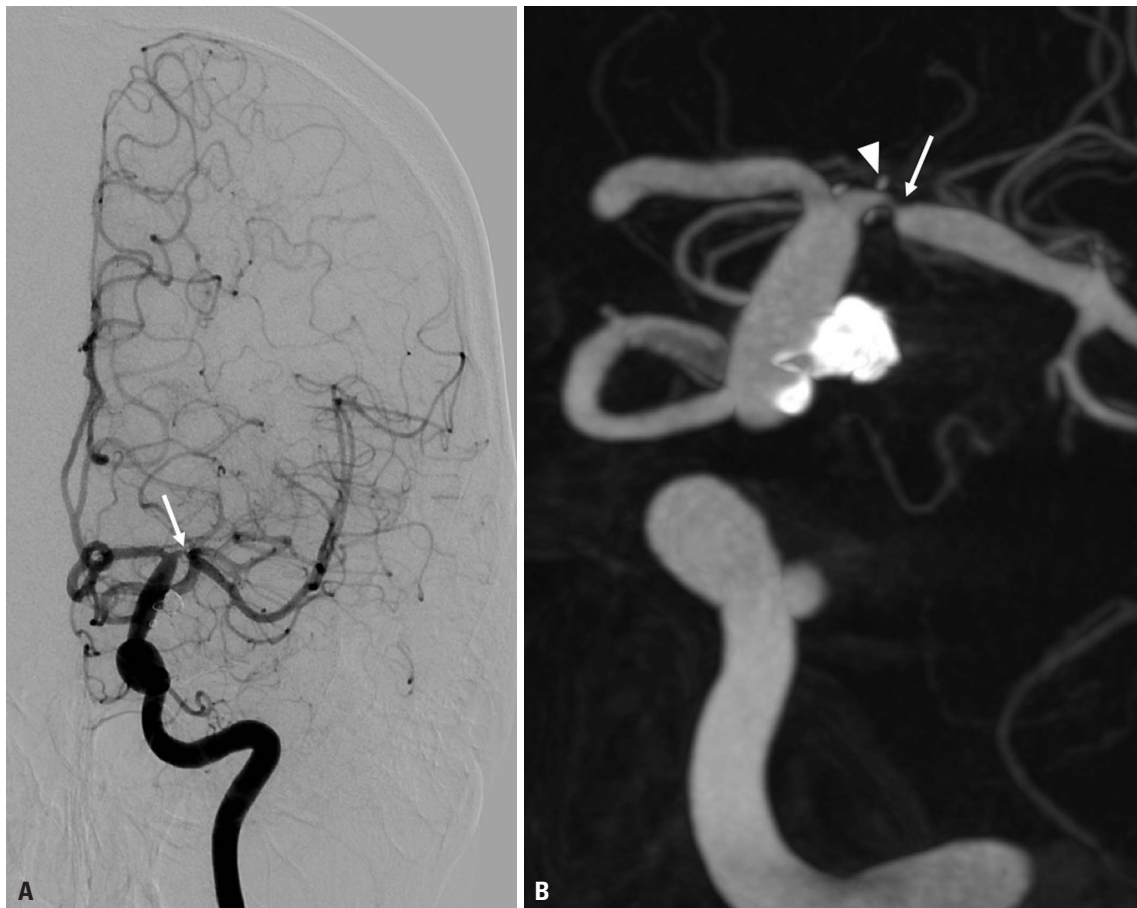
Digital subtraction angiography. (A) It showed severe stenosis (90%) of the left M1 distal to the distal end of the Enterprise stent. (B) Dyna-computed tomography showed a precise relationship between the distal end of the stent and M1 stenosis. White arrow indicates the left M1 stenosis; white arrow head indicates the distal markers of the Enterprise stent.
